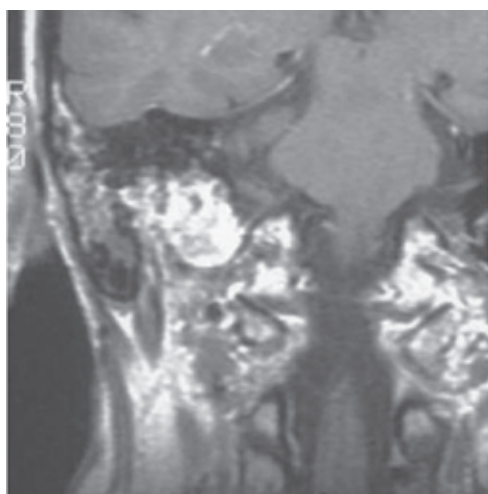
MRI Scan of a glomus tumour (paraganglioma) of jugular foramen
